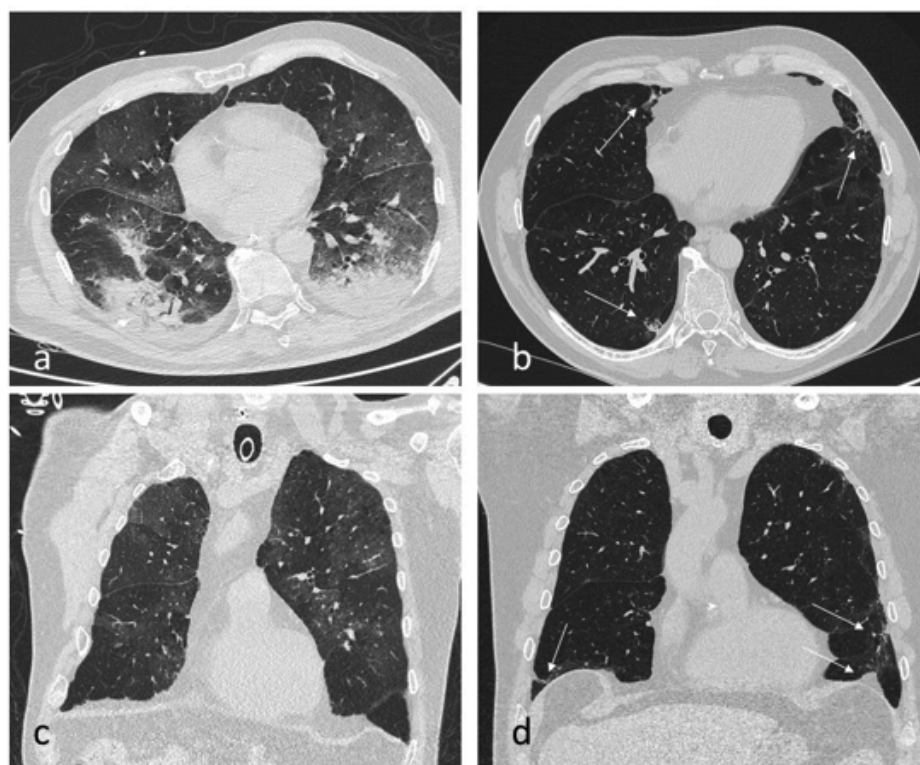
CT scan of a 69-year-old man with severe COVID-19 pneumonia. a,c) The axial and coronal thin-section scans, performed at our Emergency Department, showed multiple bilateral ground-glass opacities and parenchymal consolidation. b,d) The axial and coronal thin-section scans obtained 547 days after the first acquisition showed the persistence of some parenchymal bands.
